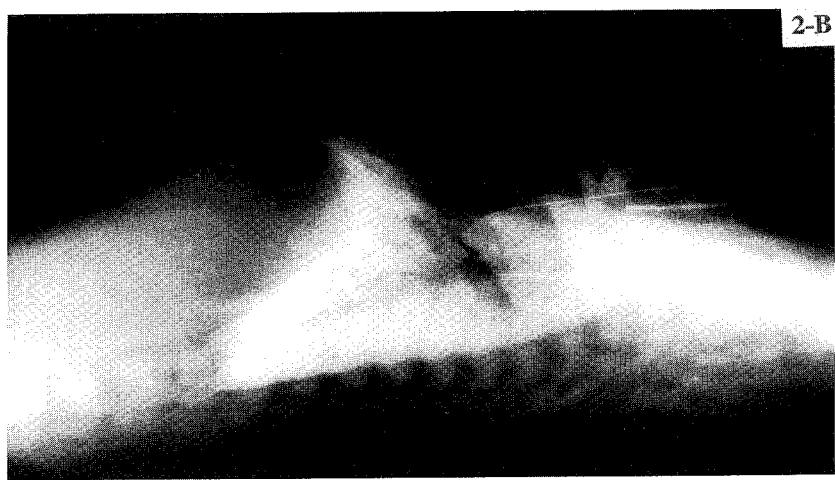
HRCT image of isolated *in vitro* neonatal lamb lung before (A) and after (B) tracheal instillation of 10 ml/kg of perflubron. Short thick arrow: thickened interstitium around central bronchus; opened short arrow: air:fluid level, note lack of bronchial wall coating in unopacified portion; short small arrows: opacified pulmonary lobule with entral high density representing perflubron filled centrilobular brnchial. Diffuse punctate and linear high densities represent multiple small airways at varying obliquity with the plane of imaging.
